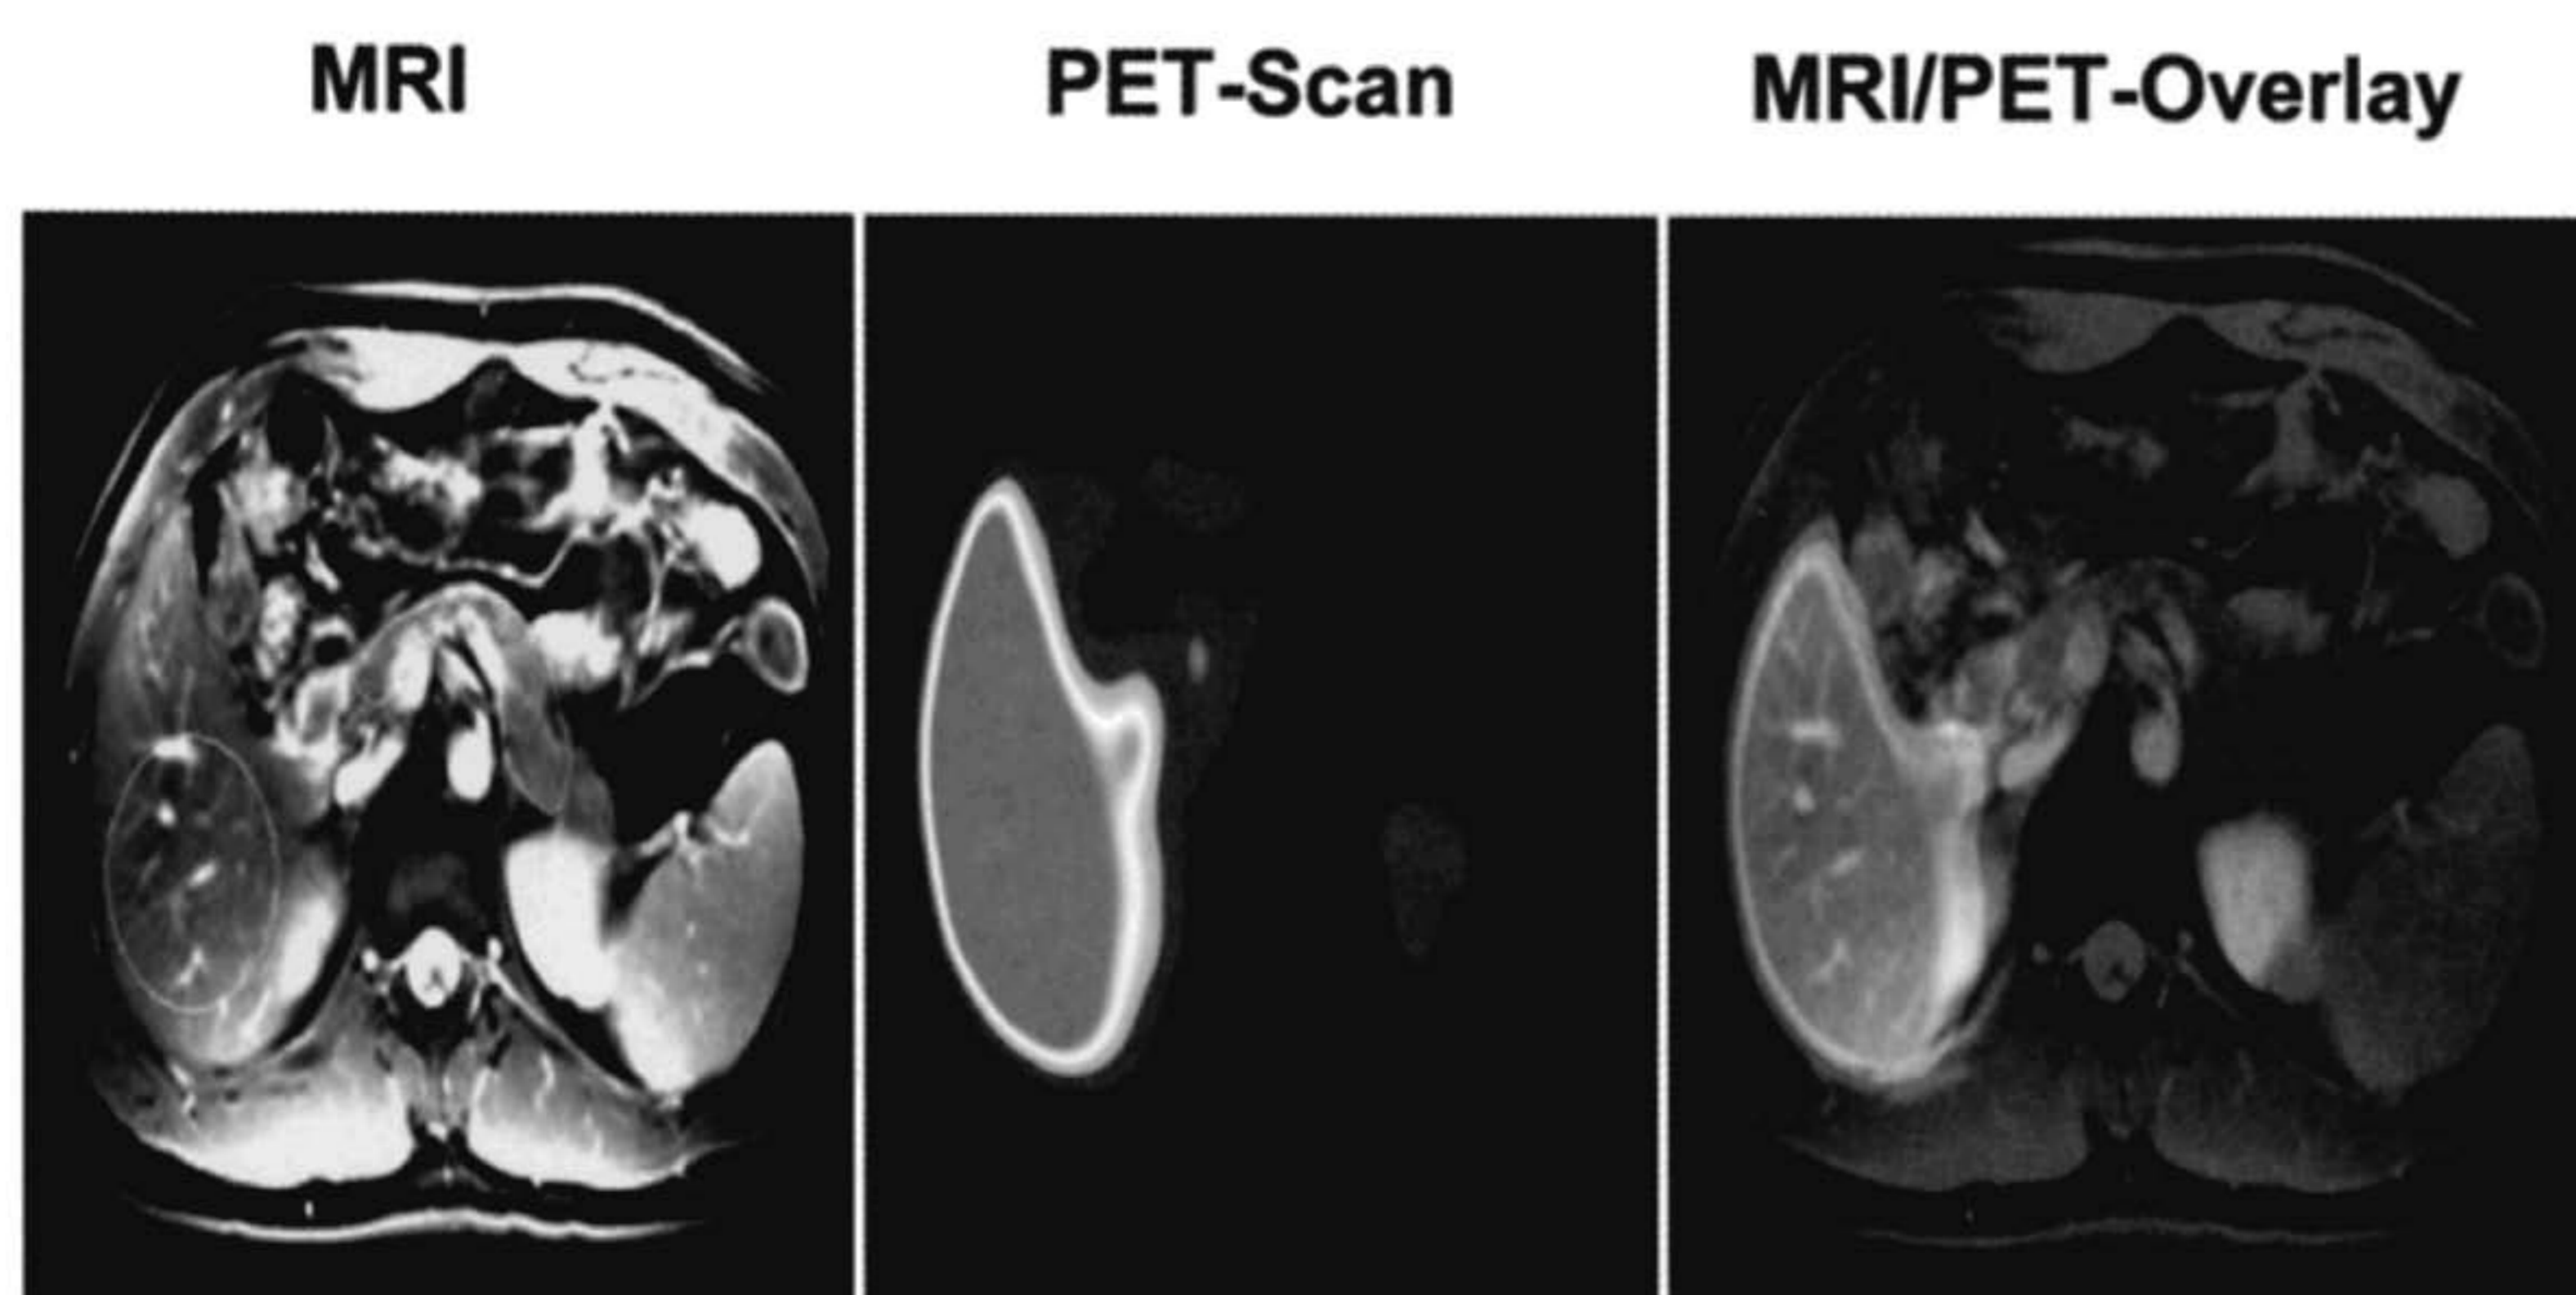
MRI, PET-Scan, and MRI/PET-Overlay in a healthy volunteer. With magnetic resonance imaging (MRI), the liver and pancreas were easily detected. Afterwards, regions-of-interest (ROI) were manually drawn in the 3D MRI data and superimposed onto the realigned PET data. MRI/PET-Overlay shows high radioactive signal in the liver, but no visible radioactive signal in the pancreas.
